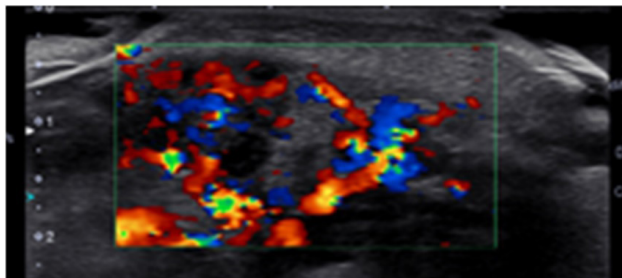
Color doppler sonographic image of the right parotid region.
